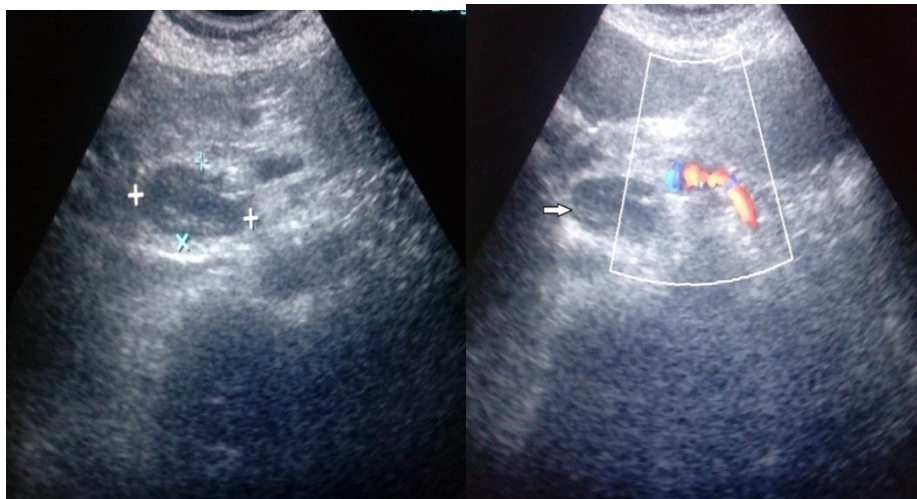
Ultrasonography images showing a well-defined hypoechoic lesion in pancreatic head.
